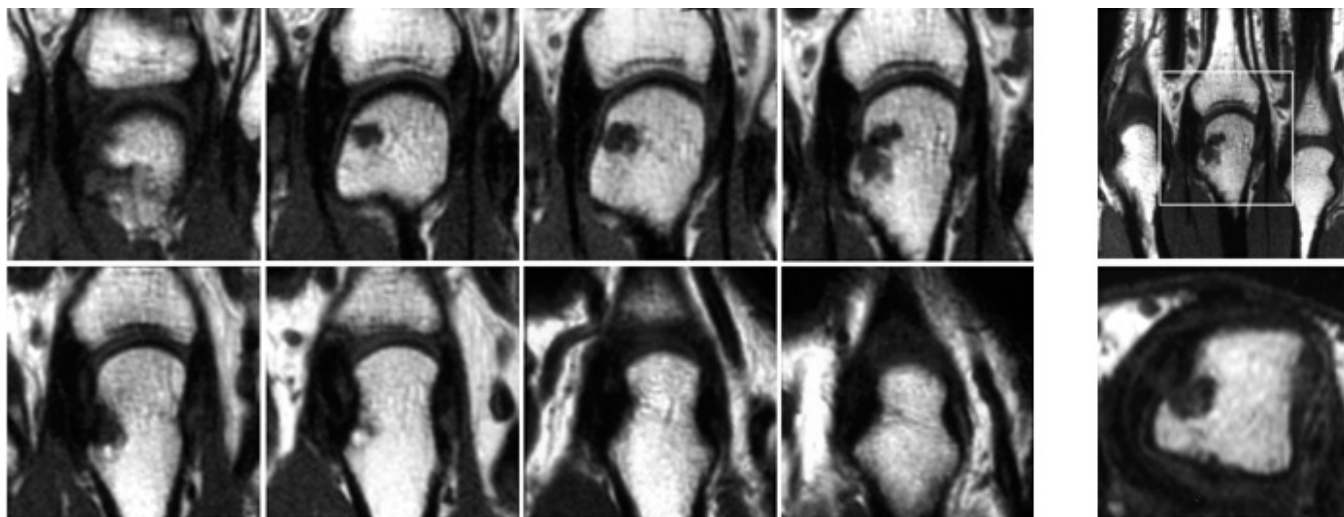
Grade 2 bone erosion in the third metacarpal head, according to the EULAR-OMERACT RA MRI reference image atlas. The 8 images at left are adjacent coronal slices through the metacarpal head. From these coronal images the percentage of eroded bone, as compared with the volume of original bone from the joint surface to a depth of 1 cm, is estimated. In this case, the erosion volume is estimated to be within the 11–20% (grade 2) range. The 2 images on the right are a coronal scout image (top) and an axial image (bottom) to confirm that the erosion, as required by definition, is visible in 2 planes.
